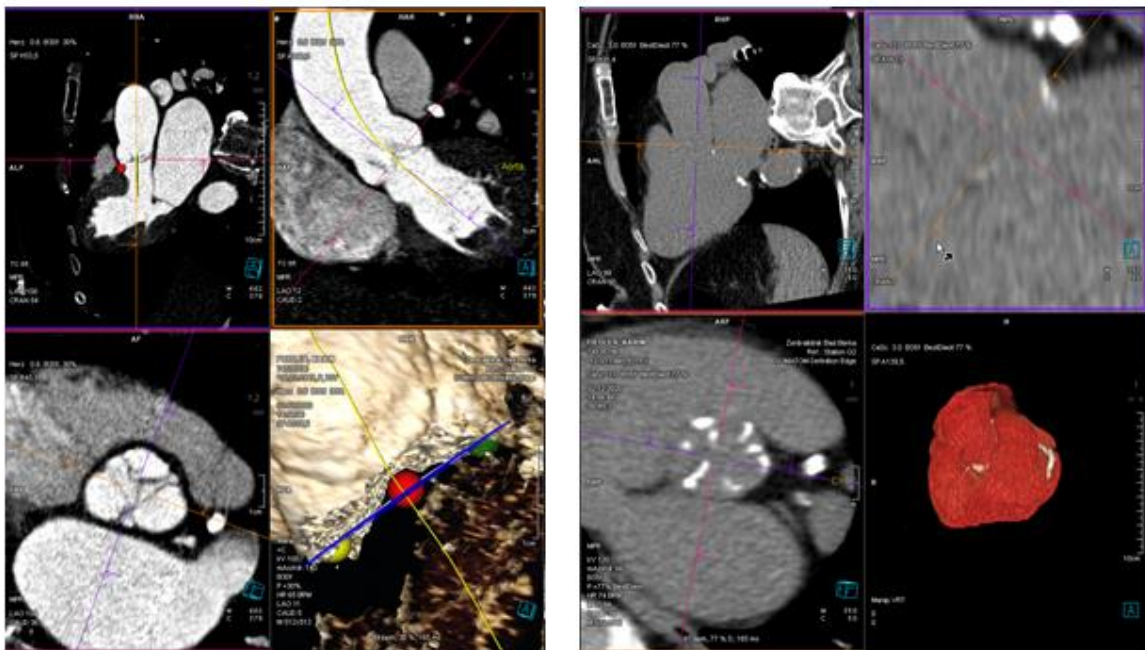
the difference between the estimations of 3-cusps view in CT with and without contrast medium.
